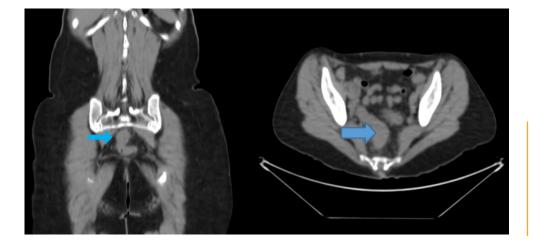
Coronal and axial reformatted images of an unenhanced CT scan of the abdomen and pelvis showing mild circumferential thickening of the wall of the sigmoid.
